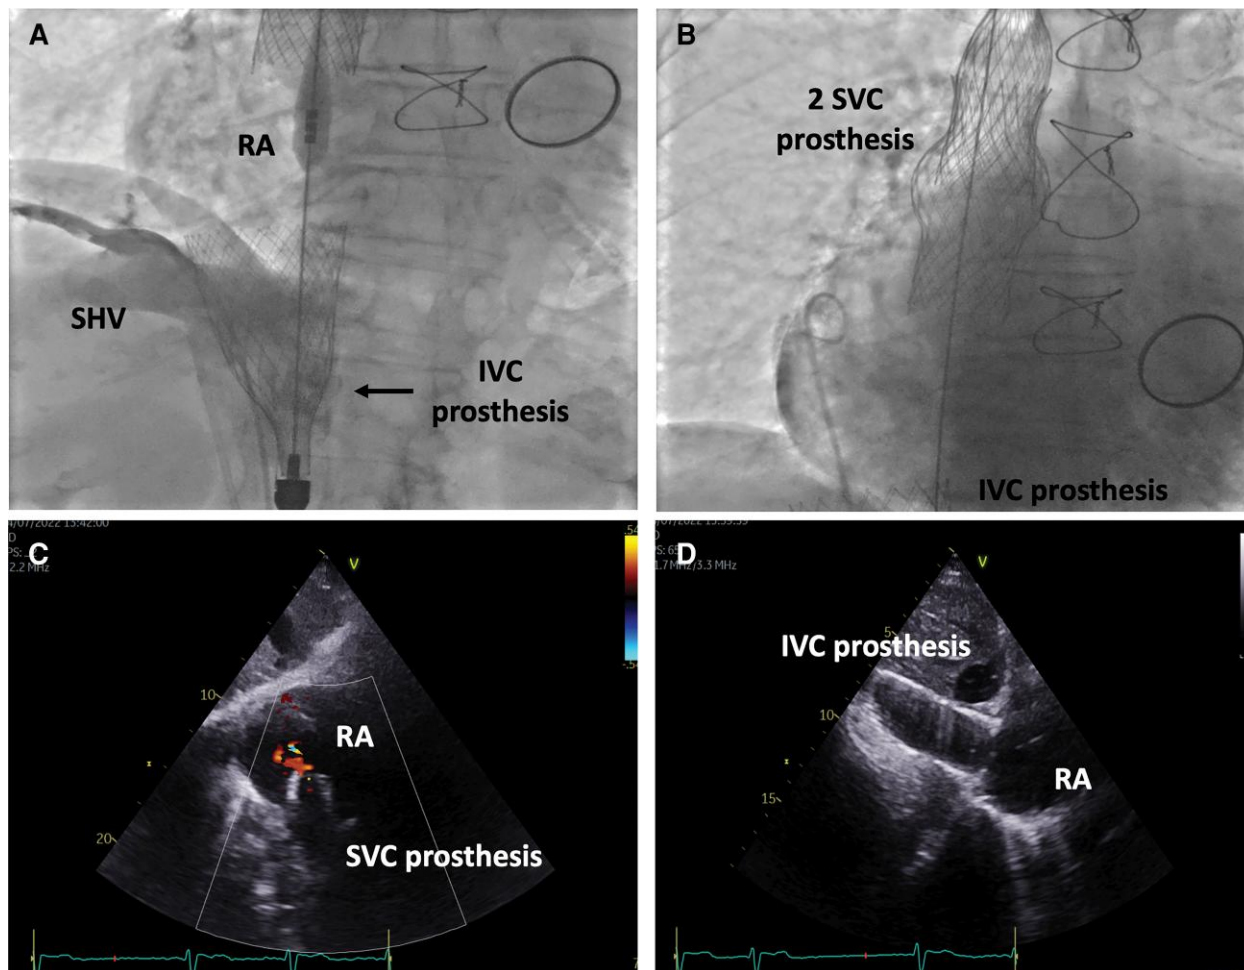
Fluoroscopic images of inferior vena cava valve delivery and post-procedural echocardiogram of Patient 2. (A) Inferior vena cava valve delivery under fluoroscopic guidance with caution to avoid occlusion of the supra-hepatic veins. (B) Final venous angiogram without significant peri-prosthetic leaks in the caval valves. (C, D) Post-procedural transthoracic echocardiogram showing a partially migrated prosthesis in the superior vena cava, without peri-prosthetic leak or tricuspid obstruction and a well-positioned inferior vena cava valve. RA, right atrium; SHV, supra-hepatic veins; IVC, inferior vena cava; SVC, superior vena cava.
